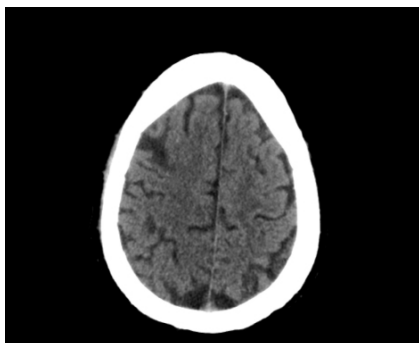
Noncontrast-enhanced CT of the head showing a small, hypodense lesion in the right frontal lobe suggestive of a chronic infarct.
